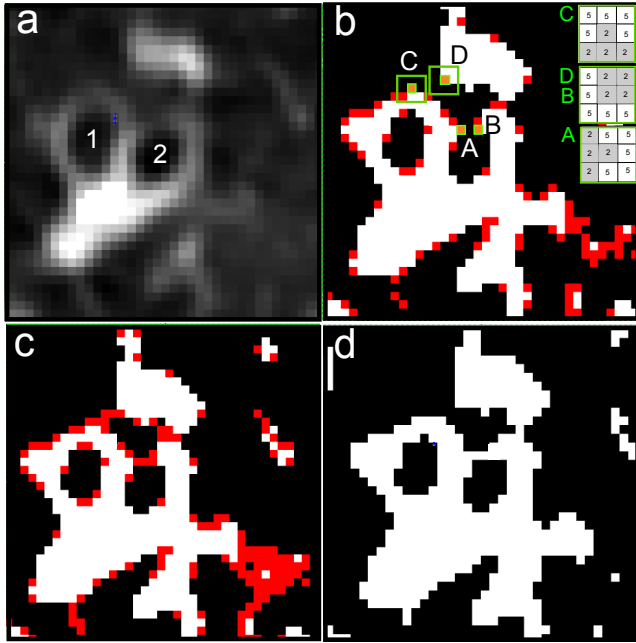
a) Part of a CT slice with two bronchi; b) Segmented pixels (grade 0 in black, grade 1 in red, grade 2 in white) and two pairs of border pixels A-B and C-D (in orange) and the masks used to identify them; c) As a result of the connection process, the pixels connecting the pairs of border pixels have been set with grade 1 and are shown in red; d) Final decide step using intra-slice information: the pixels closing the wall of bronchus 2 have correctly changed to grade 2 and shown in white; other uncertain pixels have correctly been changed to grade 0 and are shown in black.
